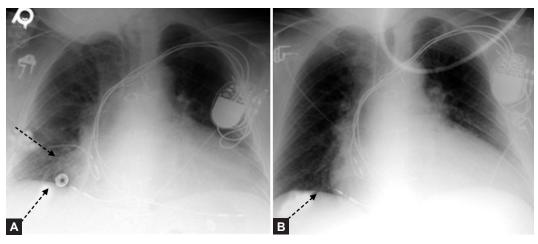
and B (A) PA view of chest X-ray; (B) AP view of chest X-ray
